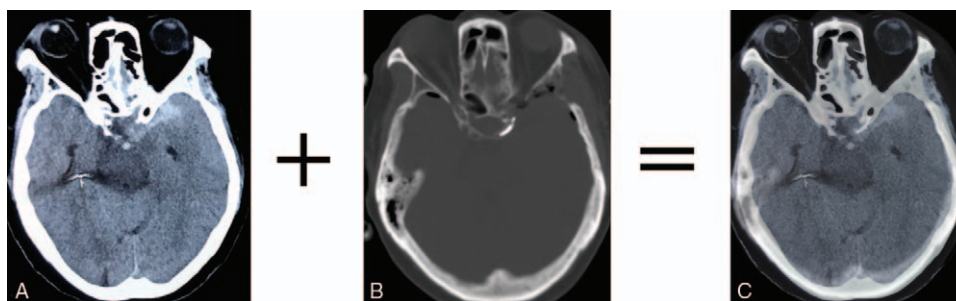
Post-operation image view after the neuroendoscopic surgery. A. The pre-operative CT scan showed that the ACP was buried in the SAH. B. The post-operative CTA showed that the ACP had been removed. C. The merged picture shows that the aneurysm clip was correctly located at the ACP area. CT=computed tomography, CTA=computed tomography angiography. ACP=anterior clinoid process.
